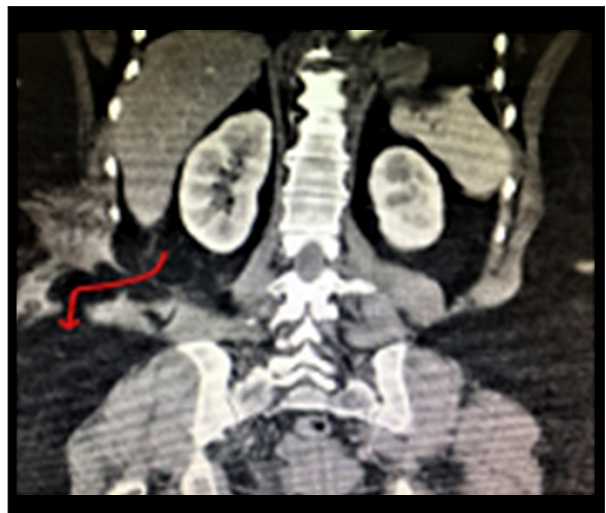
Coronal CT image of the abdomen. This CT image of the abdomen shows the right traumatic abdominal wall hernia (Arrow: depicting the path of the hernia defect).
